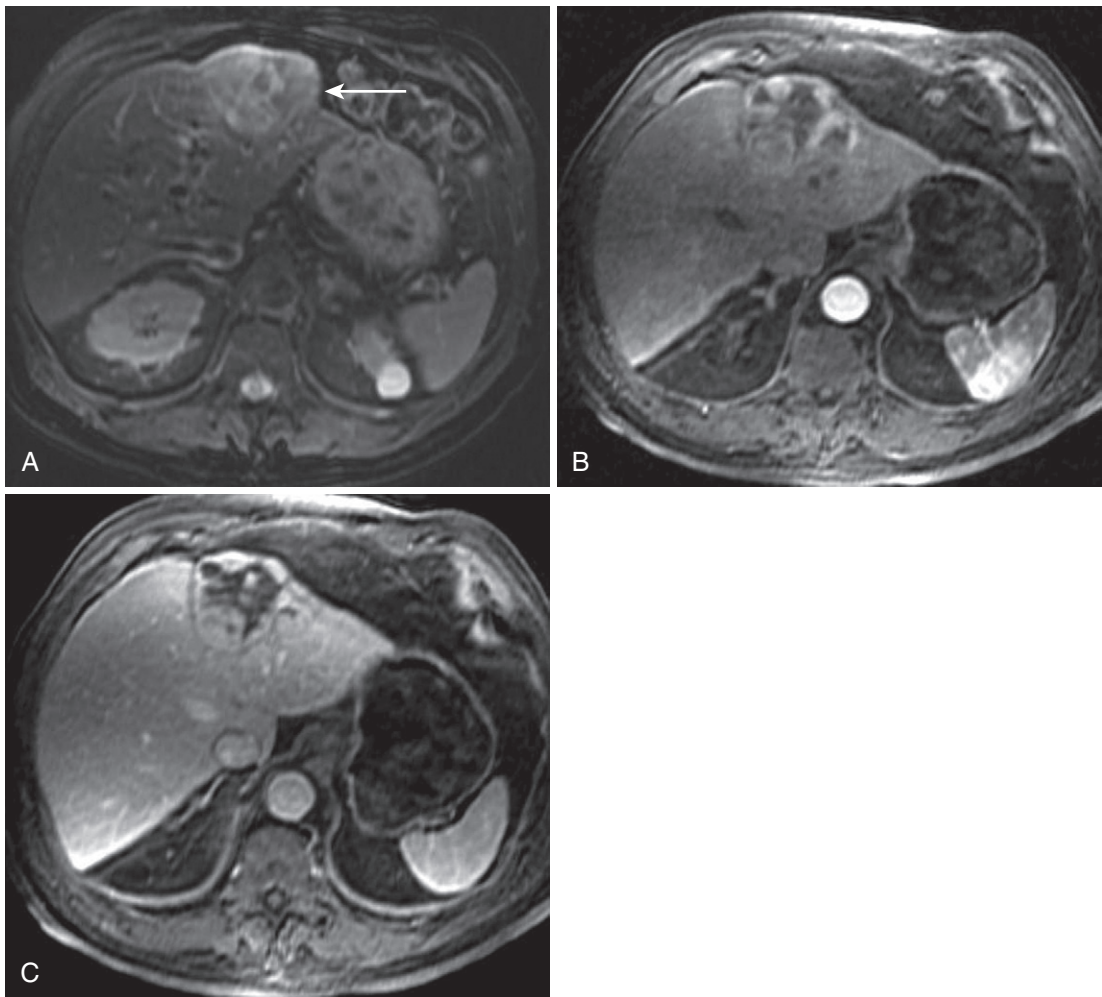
Large complex HCC. A, The moderately T2-weighted image shows a large heterogeneously hyperintense lesion (*arrow*) bulging the liver capsule. The arterial phase (B) and delayed (C) images show variegated enhancement, often seen in large lesions.
